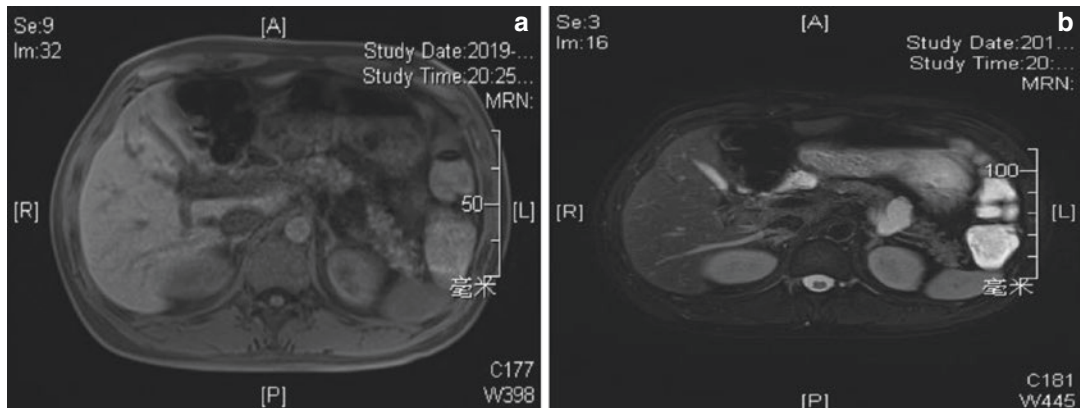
(a, b) T1WI and T2WI of abdominal MRI. (c, d) Arterial and venous phase of abdominal MRI
